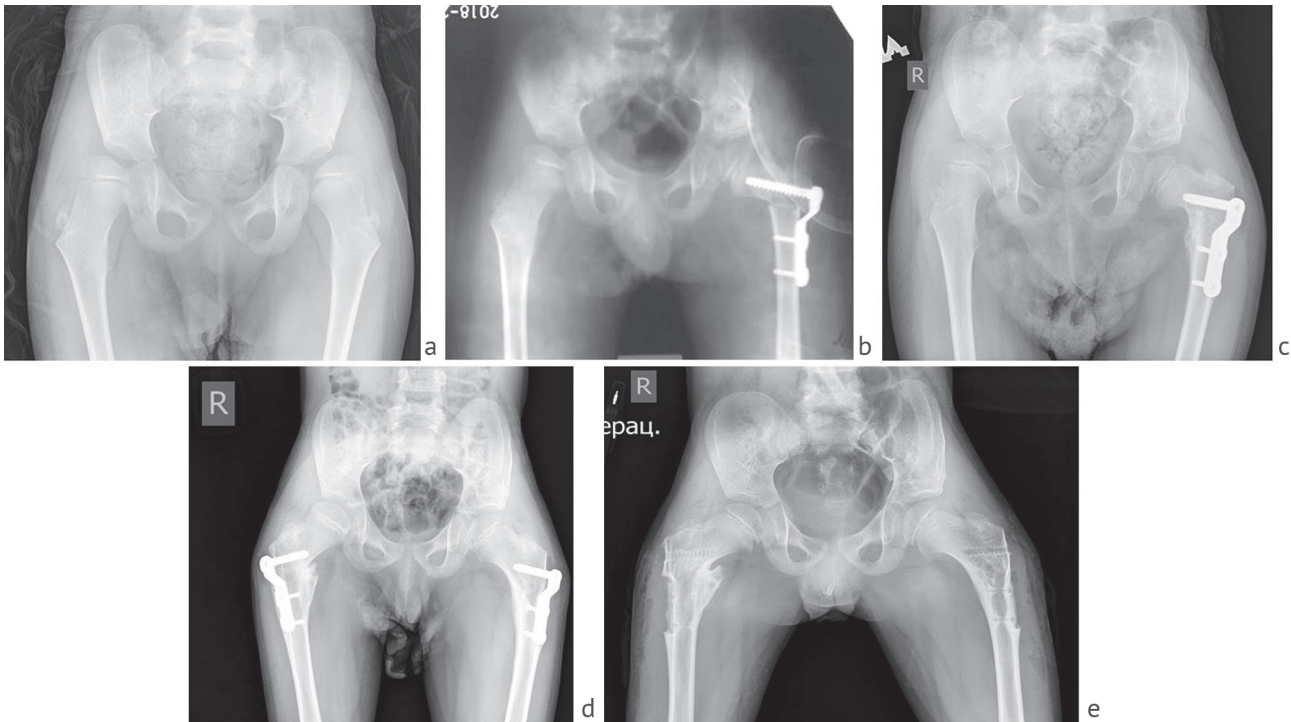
Bilateral reconstruction of hip joints with a period between operations of 1–1.5 years. Patient M., 4 years old, GMFCS level IV. AP radiographs of the pelvis: a before surgery: Reimers index 38 % on the right and 73 % on the left; AI 26° on the right and 33° on the left; ADI 4.0 right, 5.2 left; b after surgery on the left side: Reimers index 0 %; AI 17°; ADI 4.6; Wiberg angle 34°; c 1 year after surgery on the left: Reimers index 30 % on the right; 0 % on the left; AI 30° on the right, 20° on the left; ADI 3.7 on the right, 4.0 on the left; Wiberg angle 32° on the right, 33° on the left; d after 0.5 years after surgery on the right: Reimers index 24 % on the right; 0 % on the left; AI 26° on the right, 10° on the left; ADI 3.9 on the right, 3.6 on the left; Wiberg angle 24° on the right, 34° on the left; e 2 years after the operation: Reimers index 0 % on the right; 0 % on the left; AI 20° on the right, 16° on the left; ADI 4.1 on the right, 4.1 on the left; Wiberg angle 32° on the right, 36° on the left
